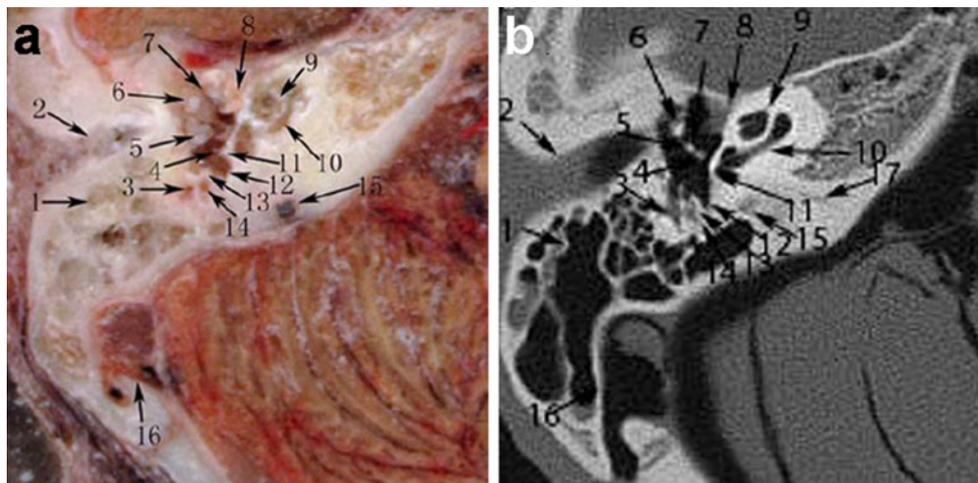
Fine structures of the temporal bone in the equivalent images from Jinan. a Sectioned image. b Computed tomograph [45]
